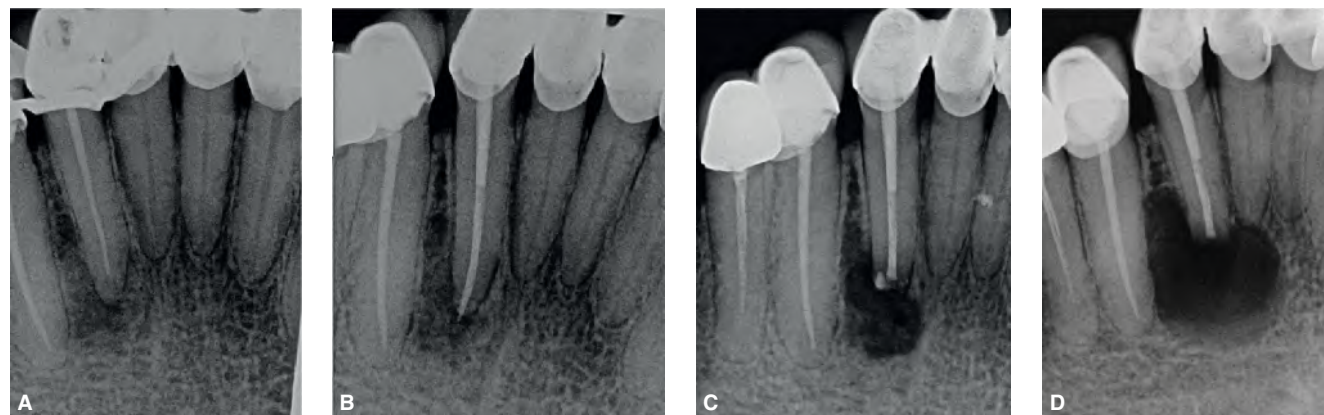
Treatment challenge in a mandibular lateral incisor. A. Preoperative radiograph. B. The tooth was retreated nonsurgically. C. At 12 months, treatment was deemed a failure. An apicoectomy was performed. D. One-year follow-up radiograph shows that the apicoectomy also failed. Possible reasons for failure include: absence of adequate seal, existence of a second canal, or vertical root fracture. Treatment options are retreatment (nonsurgically and surgically), or extraction. How would you treat this case?
